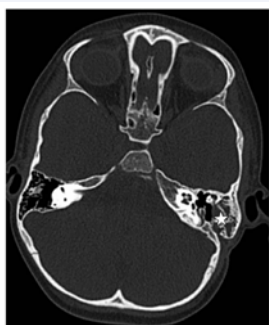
Axial CT scan of the temporal bones shows postoperative changes of the mastoid bone (star) on the left side.
